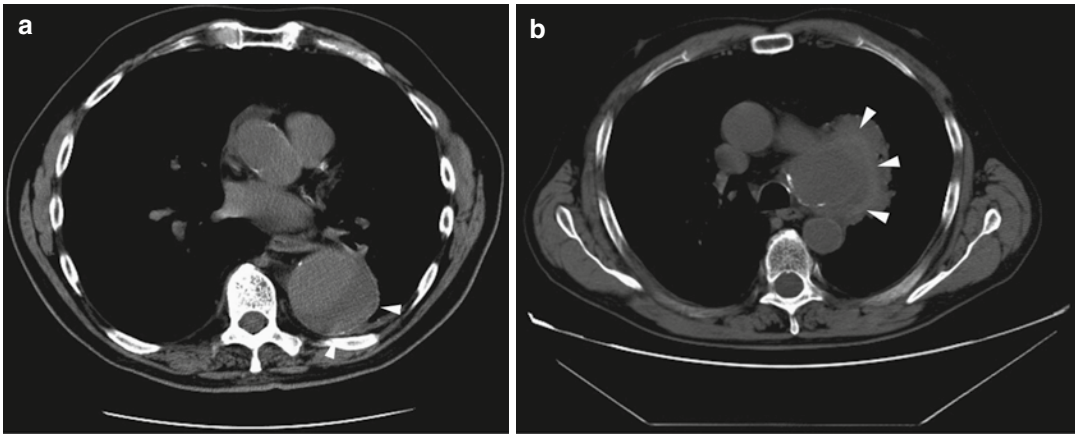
Unenhanced axial CT scan of two different patients with hemorrhage into a mural thrombus. A peripheral crescent-shaped area of hyperattenuation (arrow heads in a, b), corresponding to the hematoma into
